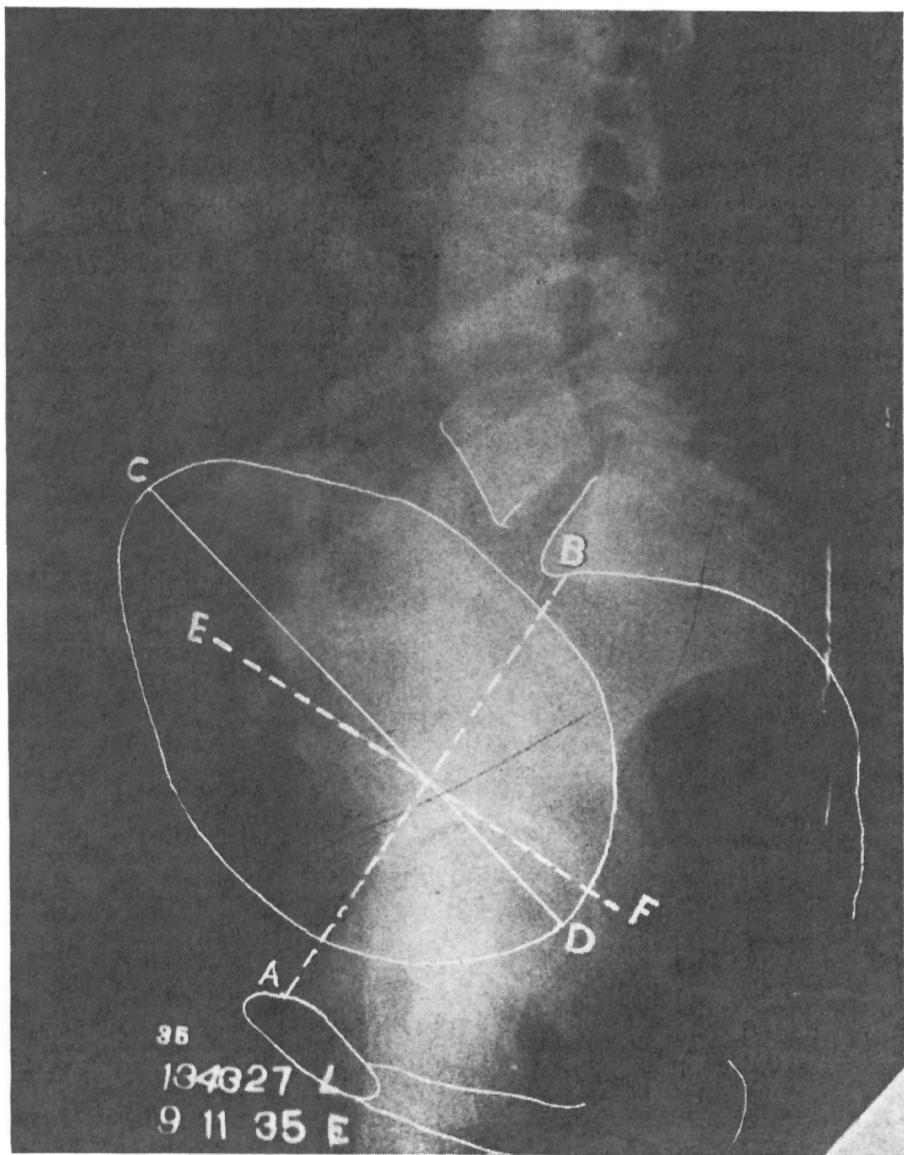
Lateral roentgenogram early in labor. A. E., First plane of inlet and true conjugate diameter. C. D., Long axis of fetal head. E. F., Perpendicular to inlet through midpoint of true conjugate diameter. The usual degree of a posterior parietal position at the inlet. This degree of asynclitism is the average at engagement. Note that C. D. slopes forward to E. F. pointing into fore pelvis.
